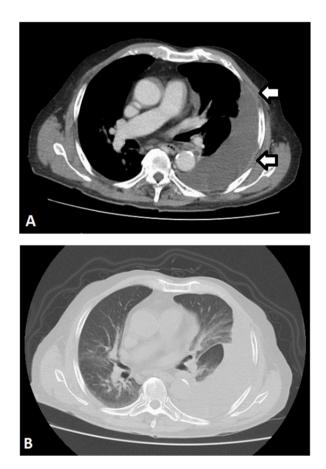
Chest computed tomography scan. (A) Left pleural effusion with mild pleural thickening (arrow). (B) No significant parenchymal abnormalities are present.
